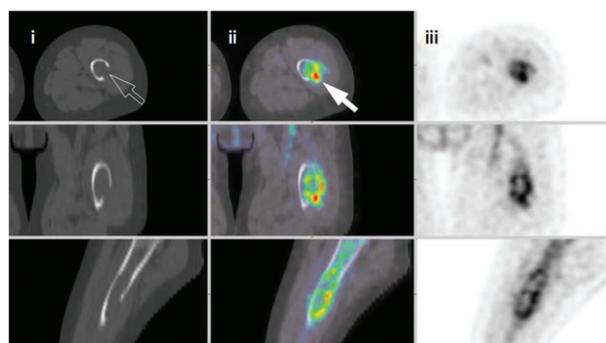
CT (left, i), fused PET-CT (centre, ii) and PET-FDG (right, iii) images of the left femoral lesion. The highest uptake of FDG is noted in the mass developed in the bone (white arrow), with subsequent lysis of the cortex (open arrow).
